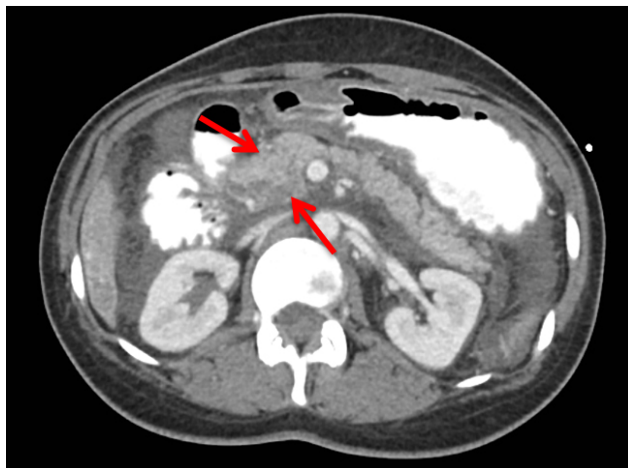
CT scan of the abdomen with contrast. Red arrows showing heterogeneous appearing pancreatic head and uncinate process suggestive of pancreatitis, with necrotic foci in pancreatic head.
